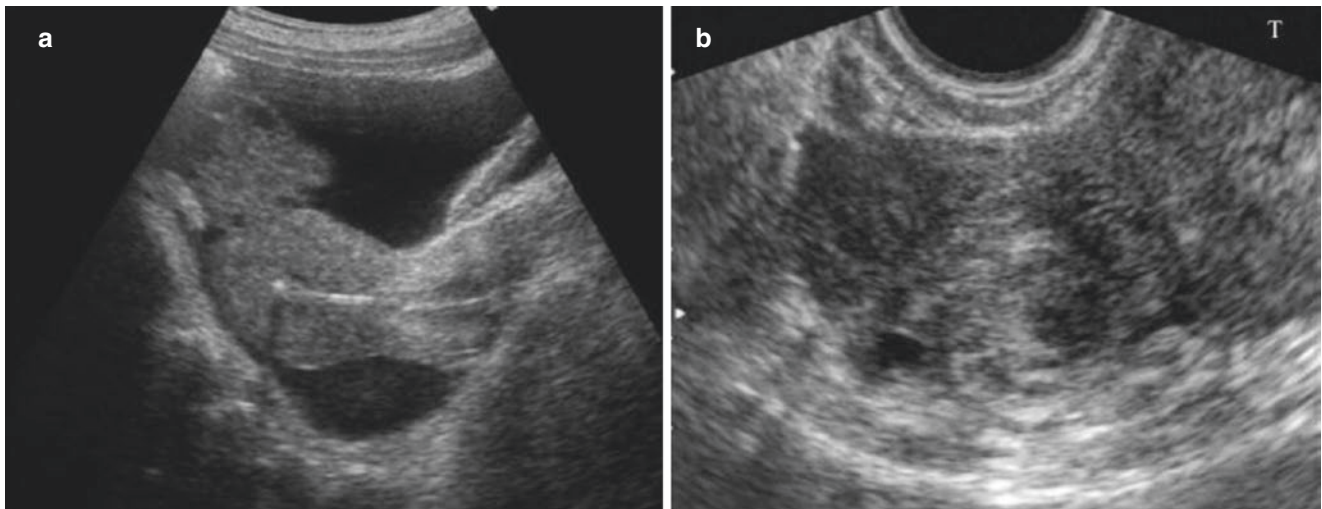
Differential diagnosis of ovarian mass and ectopic pregnancy. (a). 38 years old patient with abdominal distension for more than one month. Sonogram shows normal uterus and an irregular mass with diameter of 3.0*cm in right adnexal area. Serum CA125 is increased
